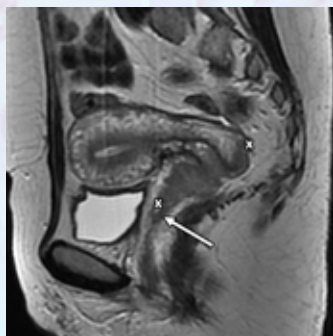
Sagittal T2-w MRI scan in a 50-year-old woman showing a 6.1cm lesion involving the cervix and anterior vaginal wall (between callipers) consistent with a stage IIA2 cancer.
